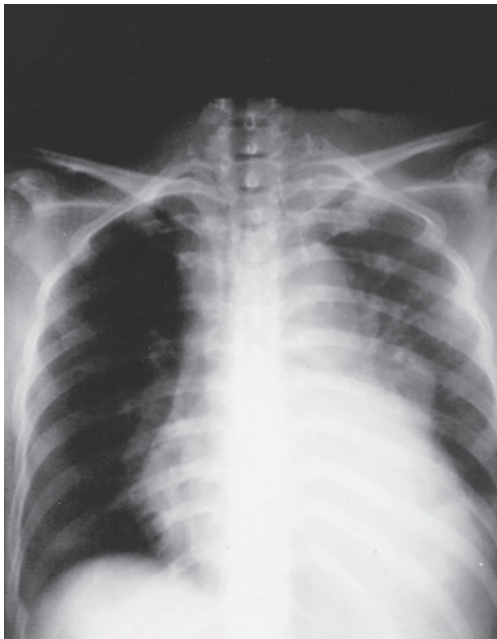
Chest X-ray on the first day showed pleural effusion on the left and markedly widened mediastinum due to enlargement of the descending aorta
